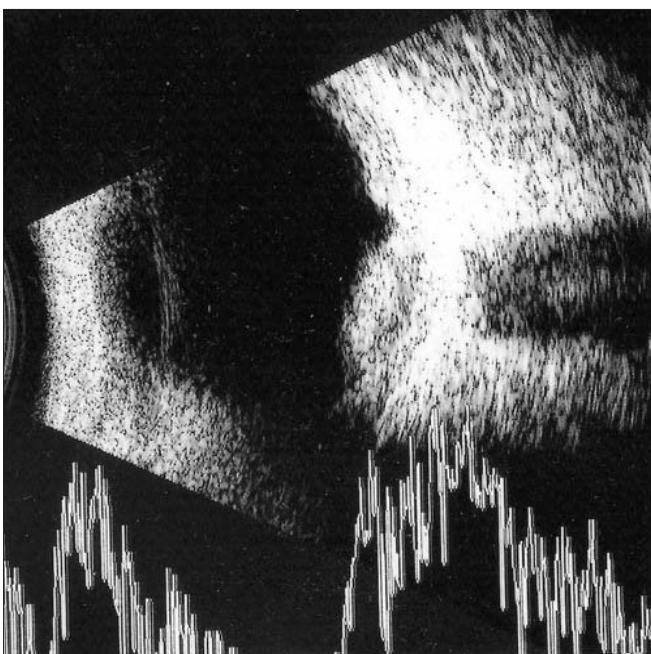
B-scan ultrasonography: dome-shaped tumor nodule, with inhomogeneous echostructure and high reflectivity.
